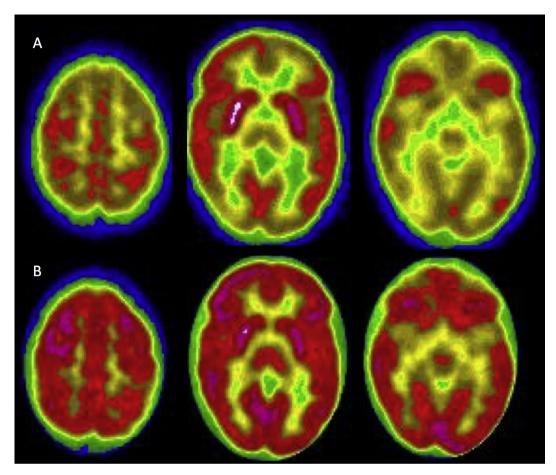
Cerebral FDG-PET features of patient 1. (A) at initial cerebral FDG-PET time point, patient 1 presented severe clinical status (mRS = 4) with extra-pyramidal syndrome, mutism, and swallowing difficulties. Initial cerebral FDG-PET showed extensive, severe cortical hypometabolism with basal ganglia hypermetabolism. (B) Second cerebral FDG-PET, after treatment showed normalization of cerebral metabolism correlated with good clinical recuperation (mRS = 1).
